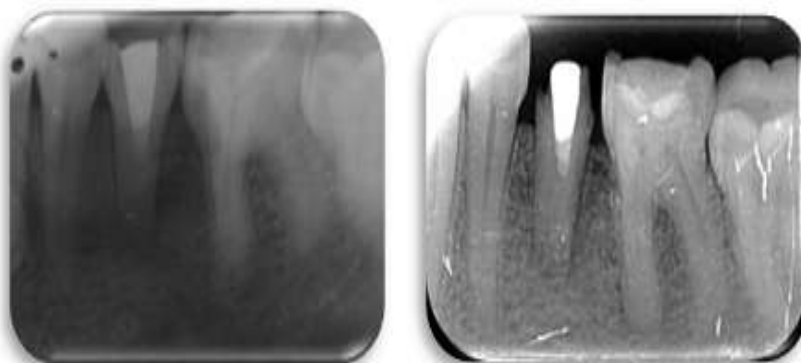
Occlusal tubercle in mandibular pre molars. Figure 2: Diagnostic IOPAR, periapical radiolucency and open apex with respect to 35.
